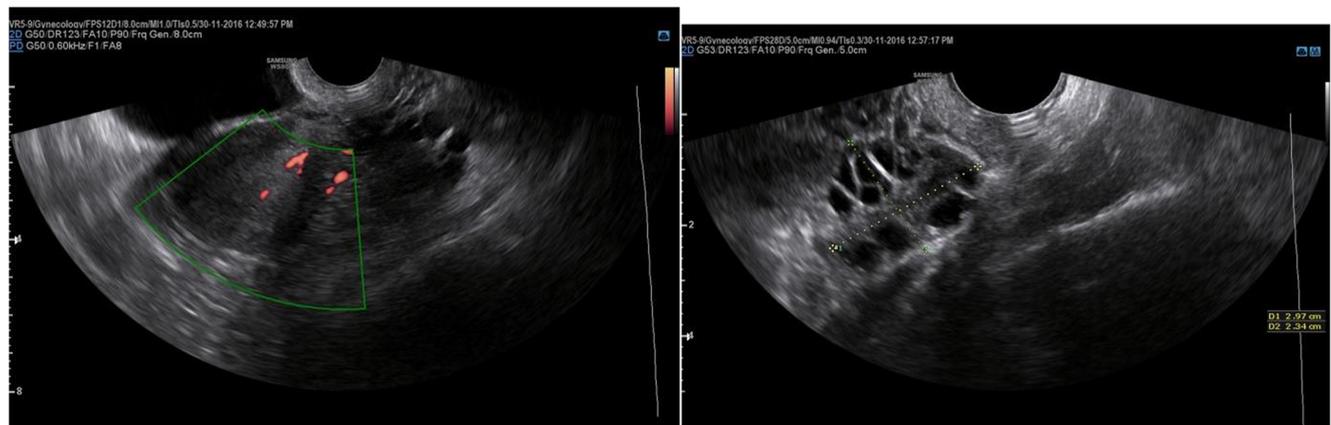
Ultrasound showing thickened smooth endometrium with cystic spaces with well defined junction and preserved myometrial thickness. myometrial invasion is suspected in cases of irregular poor defined junction in relation to one cm per wall thickness in non distended uterus
